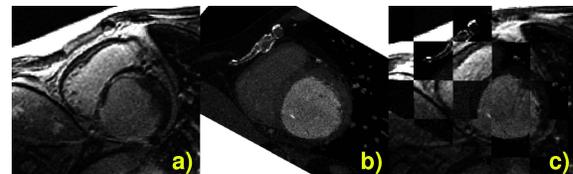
Combined view of: a) Gd-enhanced SAX, b) registered CT and c) checkerboard Gd-enhanced SAX and registered CT
